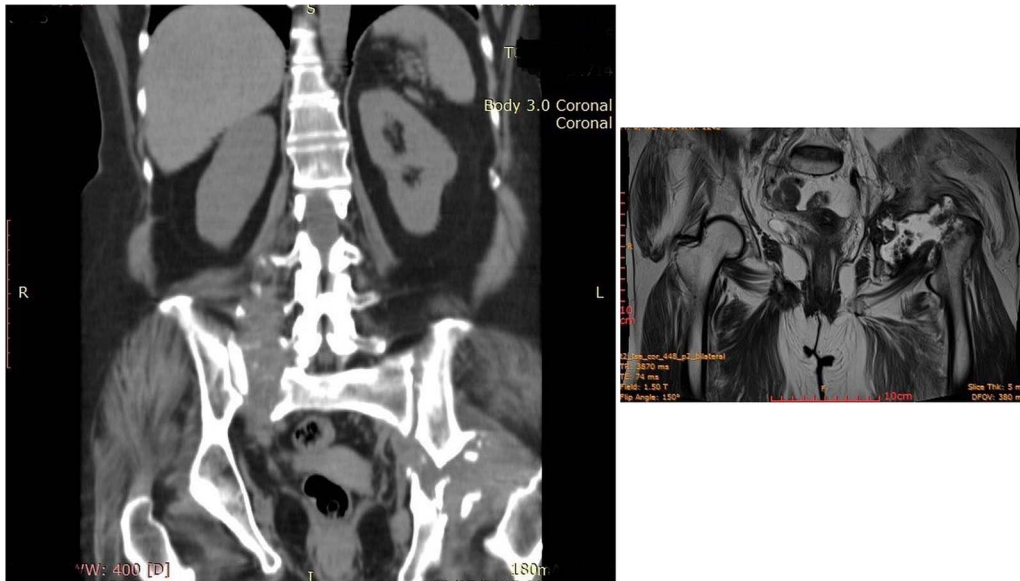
Pelvic MRI showing a complete absence of the left femoral head.
